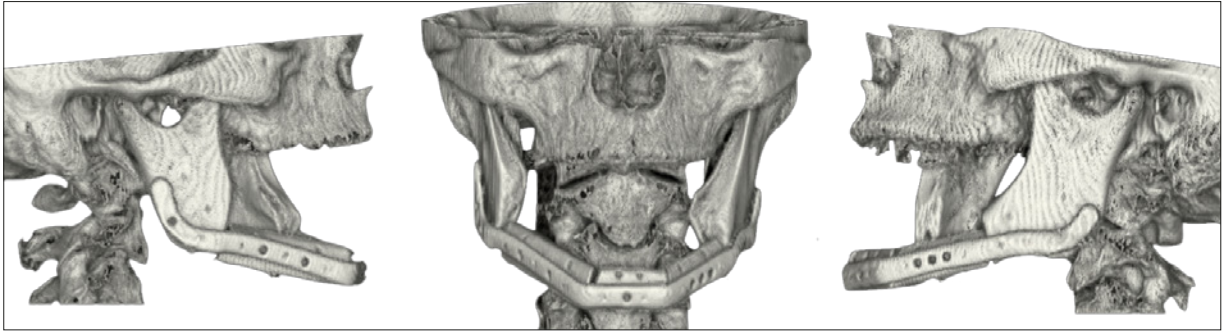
Postoperative CT scan after partial mandibular resection with simultaneous reconstruction of a fibula graft.
